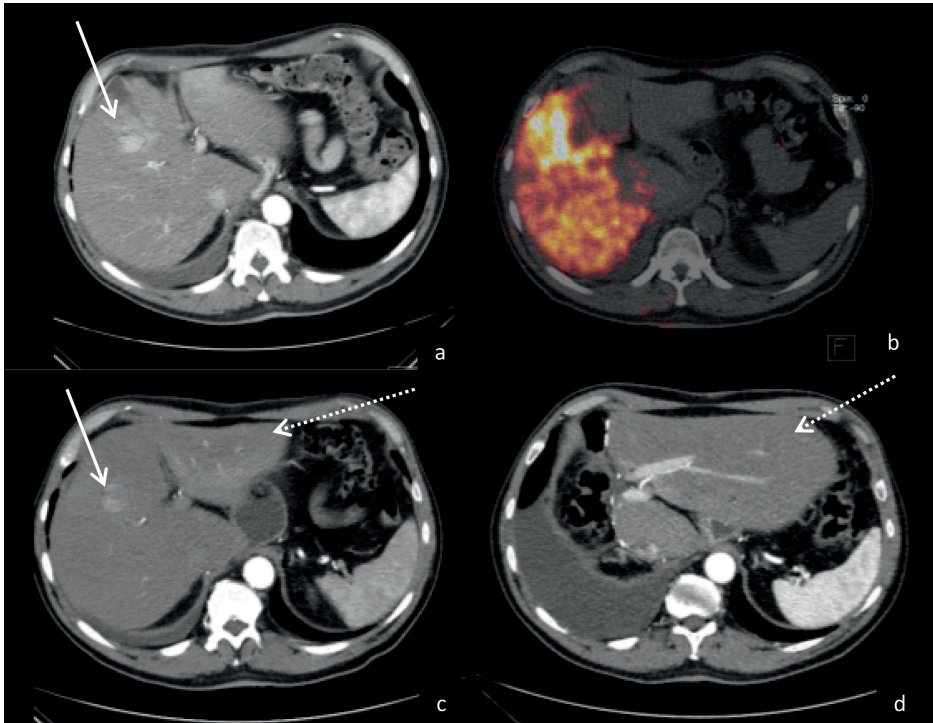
Figure a shows a contrast-enhanced CT image of a 60-year old man with an HCC (white arrow). Figure b shows the ^{90}Y -PET CT after treatment with radioembolization of the right hemiliver (120 Gy, Theraspheres). Figure c shows a CT image of a hypertrophied left hemiliver (dotted white arrow), 3 months after radioembolization. Figure d shows a contrast-enhanced CT image of the left hemiliver (dotted white arrow) 4 months after right hemihepatectomy.
